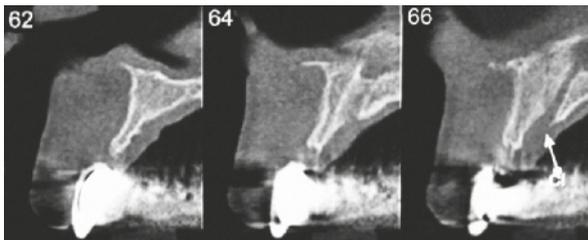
CBCT showing horizontal bone deficiency. A staged bone augmentation is indicated.
